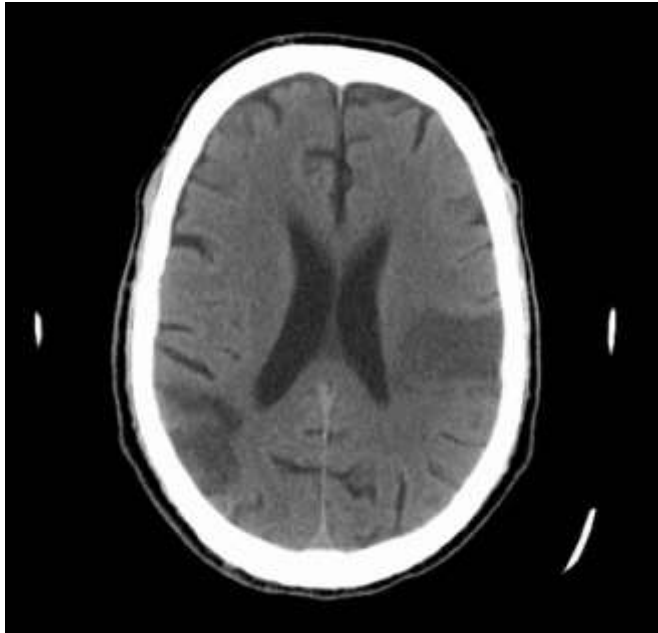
Cortico-subcortical ischemic dissemination in time and space: a previous cortico- subcortical infarct in the right hemisphere and a more recent one, on the other side (brain CT-scan).
